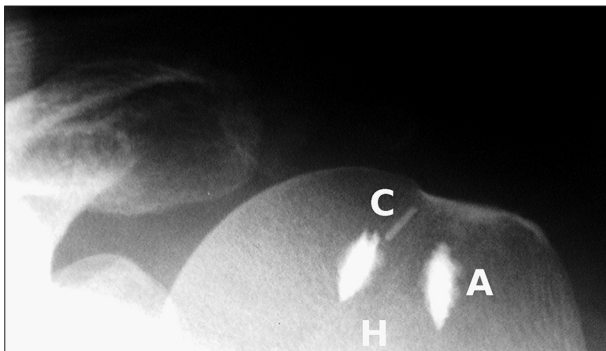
Immediate post-operative radiograph demonstrates the position of the metal marker (C) relative to the anchors (A) and humeral head (H)
